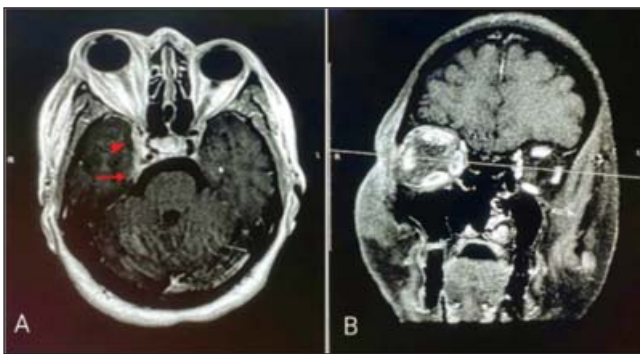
2 MRI of the brain and orbit.
